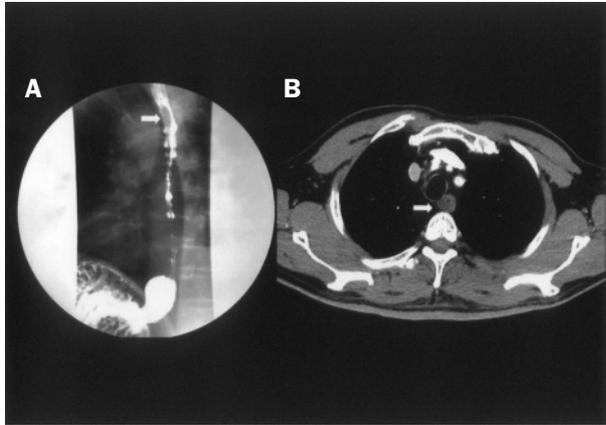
(A) Barium swallow showed a 3 × 2 cm smooth intramural tumor (arrow) in the upper part of the esophagus. (B) Computed tomography scan of the chest revealed a 2 × 1 cm submucosal tumor (arrow) with narrowing in the upper third of the thoracic esophagus.
